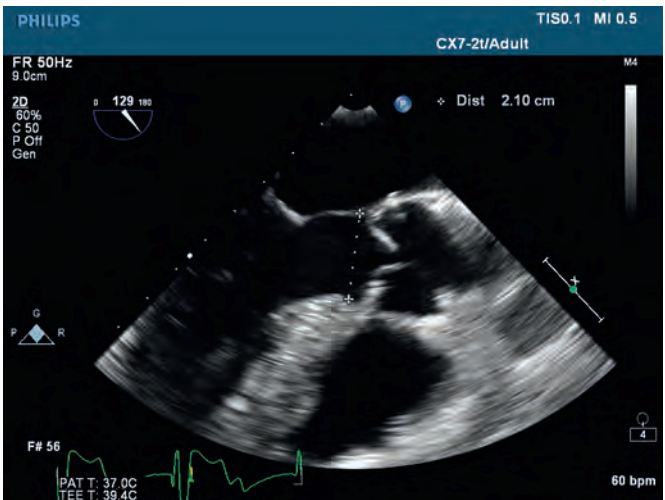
Measurement of the left ventricular outflow diameter in the echocardiographic left ventricular long-axis view. FR, Frequency.
